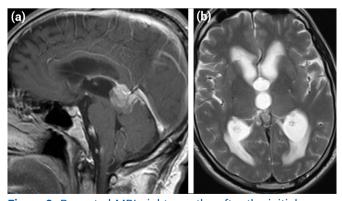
Repeated MRI eight months after the initial examination. (a) Postcontrast axial T1-weighted image shows a larger heterogeneously enhancing mass that fills the pineal region and obstructs the third ventricle outflow, causing hydrocephalus. (b) Axial T2-weighted MRI demonstrates the enlarged mass and acute hydrocephalus.
